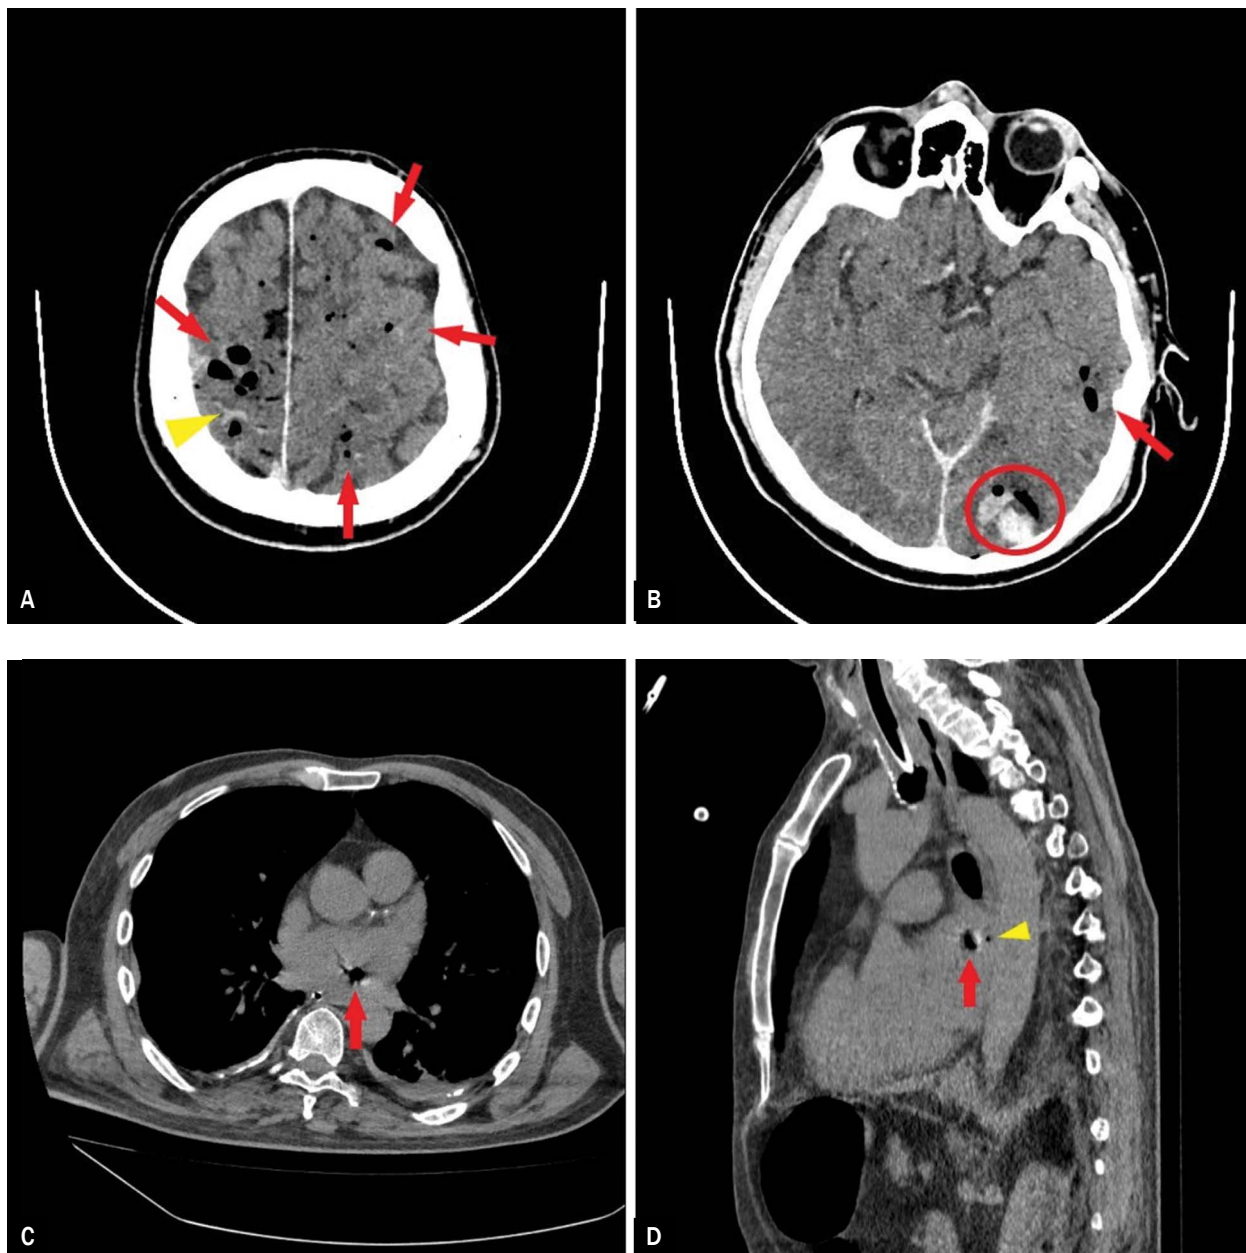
A, B. A follow-up non-contrast brain computed tomography (CT) performed right after the coronarography: multiple cerebral and cerebellar air emboli (red arrows), hyperdense material in sulci of the right parietal lobe (arrowhead), focal hyperdense areas containing small air densities (circles); C, D. Non-contrast chest CT showed gas densities in the left atrium (red arrow) and pericardial cavity (yellow arrowhead) suggesting atrioesophageal fistula (AEF) presence
